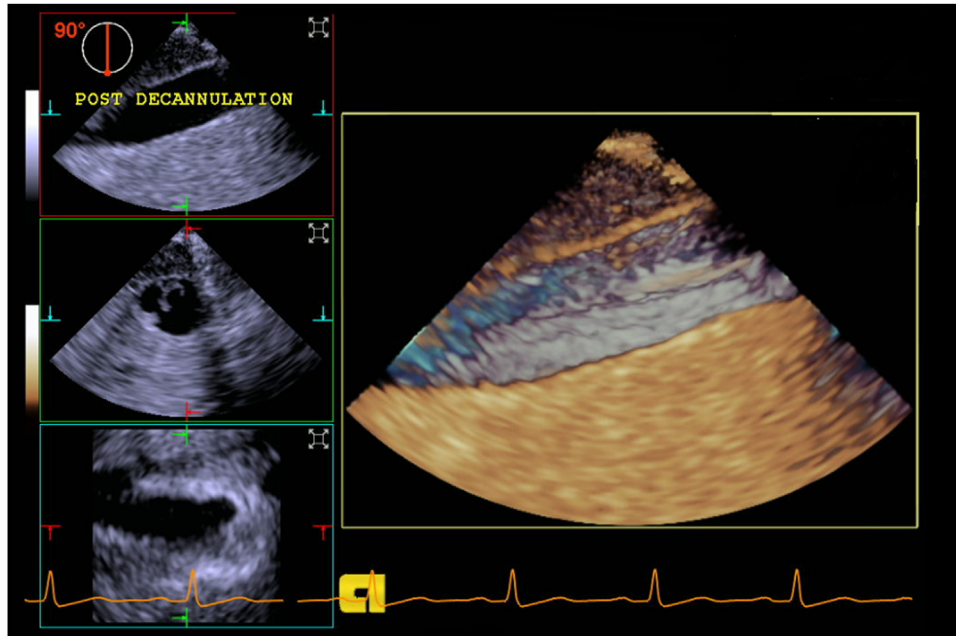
Transesophageal echocardiography (TEE) of patient 1 performed at decannulation showing fibrin sheath in hepatic inferior vena cava (IVC).
